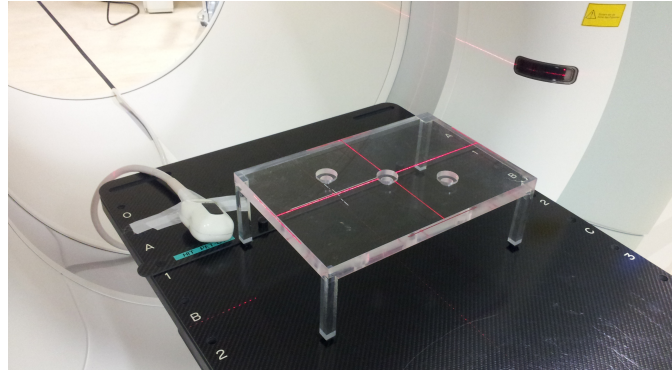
Image of the experimental set-up used to investigate the impact of the US probe on the acquired PET images. The three ^{22}Na point sources have been positioned in a diagonal line within the Plexiglass frame, aligned to the PET/CT laser system. In the depicted case, the US probe has been placed beside the source holder.
